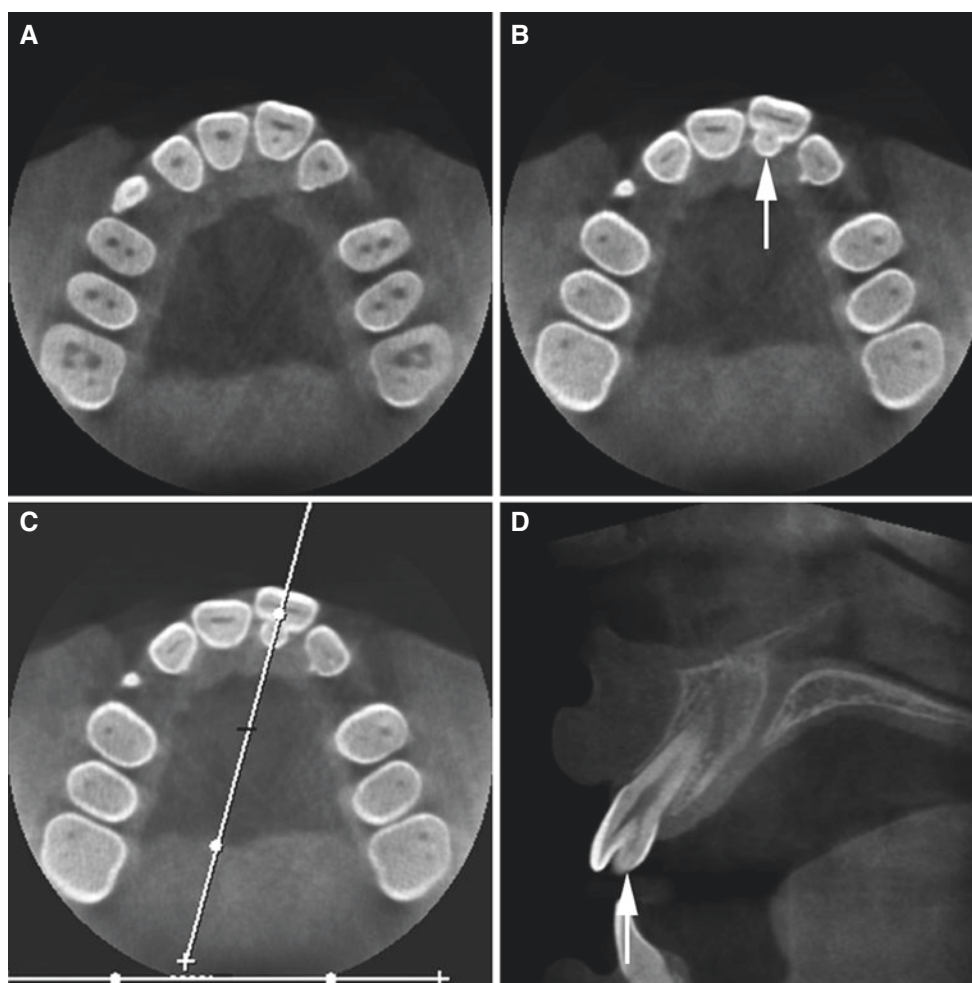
Enamel evagination (dens evaginatus, talon cusp; additional cusp or tubercle), left central incisor, maxilla; 11-year-old female. (A) Axial, (B) axial (more cranial), (C) axial (with cursor line), and (D) oblique sagittal CBCT images show cusp or tubercle with pulp horn (arrow)
